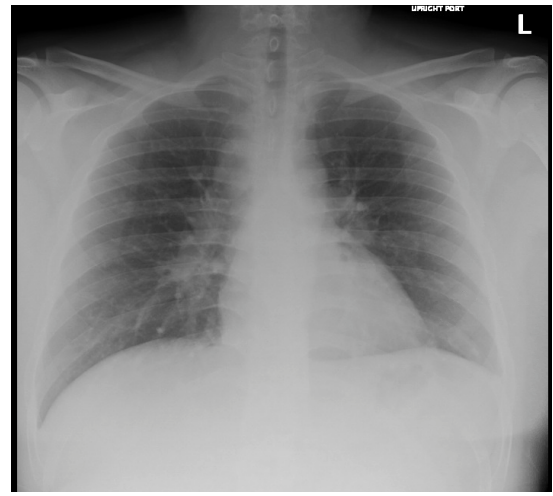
Chest x-ray showed enlarged hila and lymphadenopathy.
